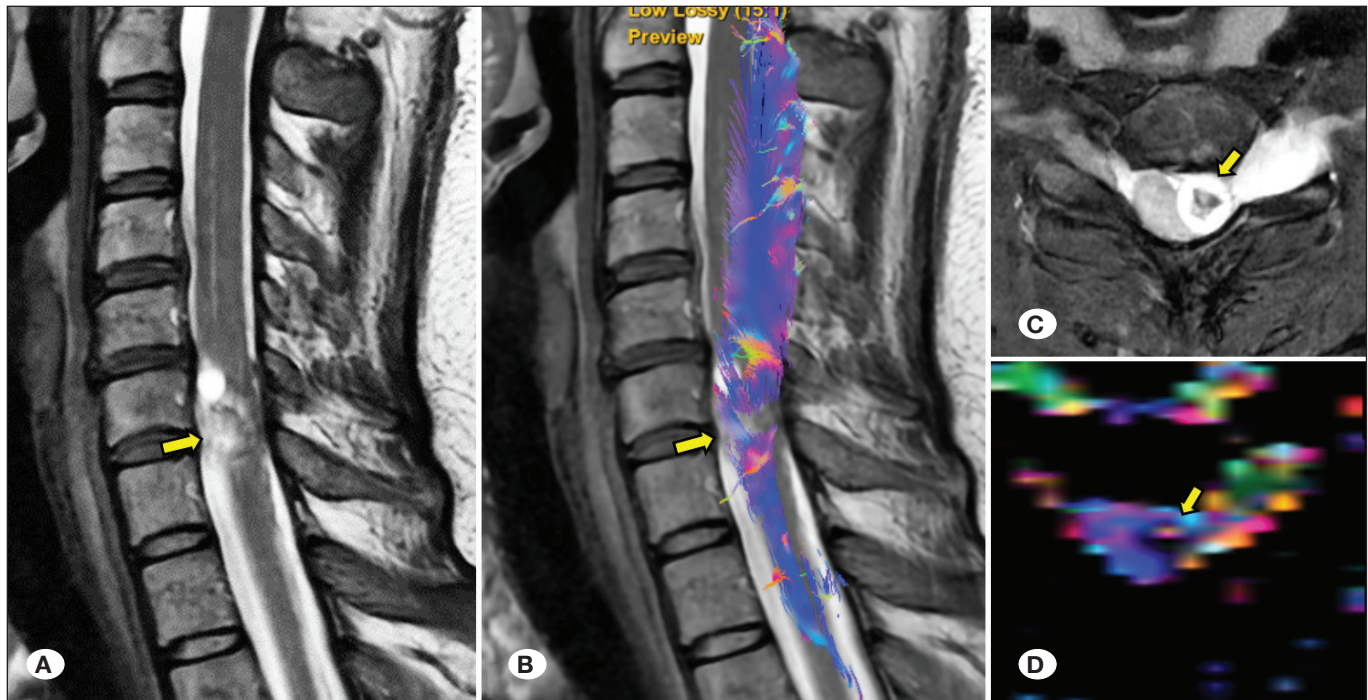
A 35-year-old woman with arm pain and numbness of the fingers showed a schwannoma with a cystic component at C6–C7 (yellow arrows) causing complete displacement of the spinal cord tract. T2-weighted sagittal image (A), tracts superimposed on a T2-weighted sagittal image (B), a T2-weighted fat-saturated axial image (C), and a color-coded FA map (D).
